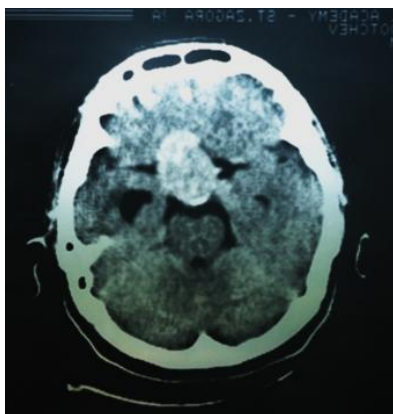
CT image of pituitary intra- and suprasellar adenoma
